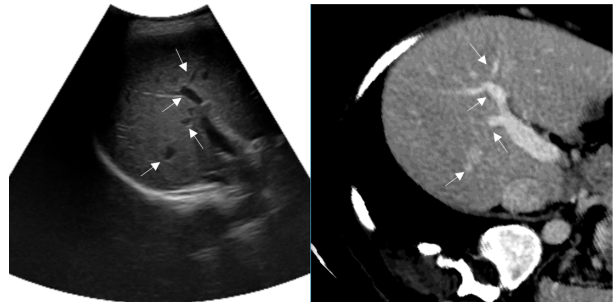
Example of registration results. left: 2D US image, right: registered preoperative CT image.
